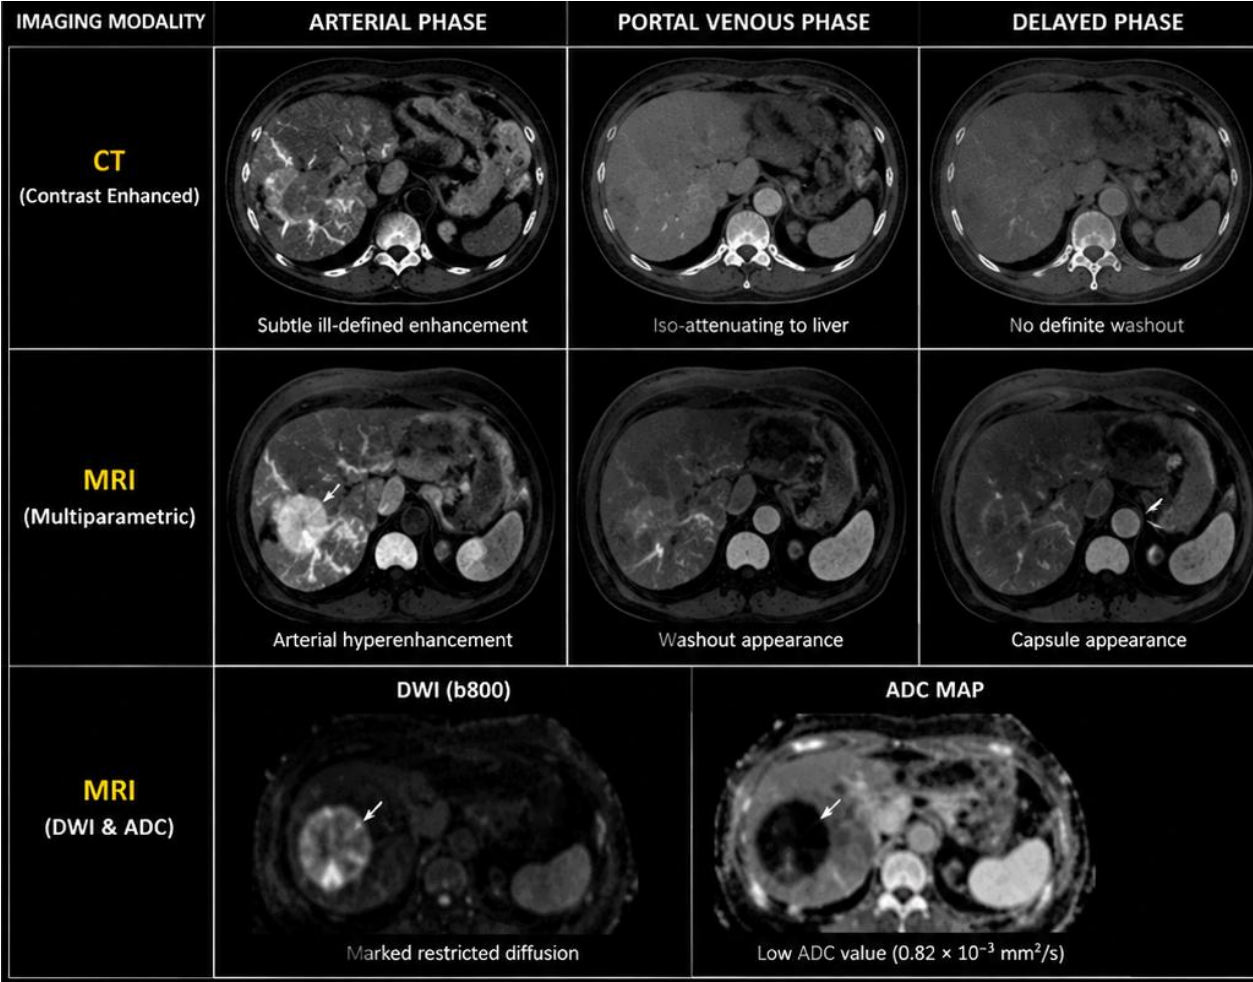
Comparative Contrast-Enhanced CT and Multiparametric MRI for Detection of Recurrent Hepatocellular Carcinoma Following Transarterial Chemoembolization
